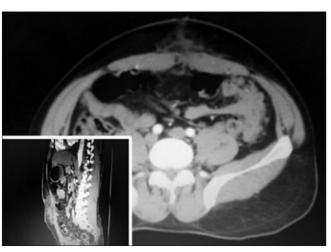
Computed tomography image shows multiple nodules and the Sister Joseph nodule
